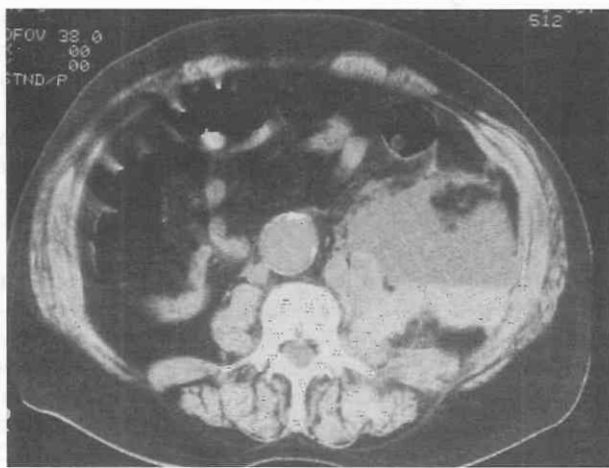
Retroperitoneal hematoma in a patient with a small abdominal aortic aneurysm. Unenhanced CT scan shows that the hematoma is separated from the aneurysm by uninfiltated fat. The patient, who had received anticoagulation therapy, experienced sudden flank pain soon after cardiac catheterization.
